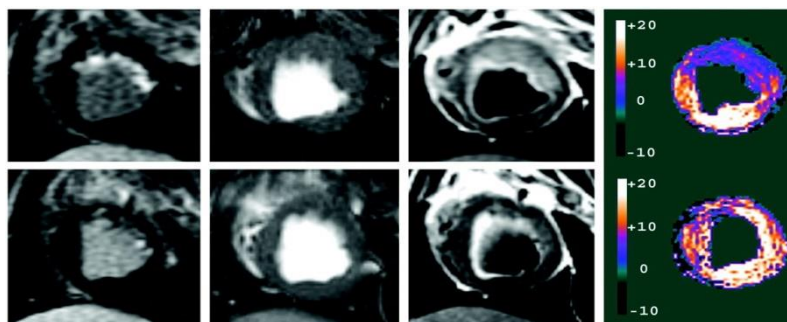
MRI findings in subendocardial infarction. Aletras AH. et al, 2006
